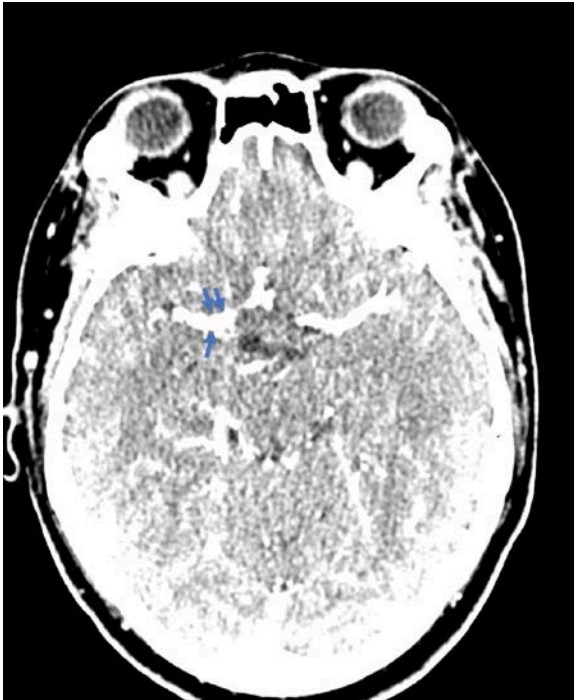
Brain CT with and without contrast.
